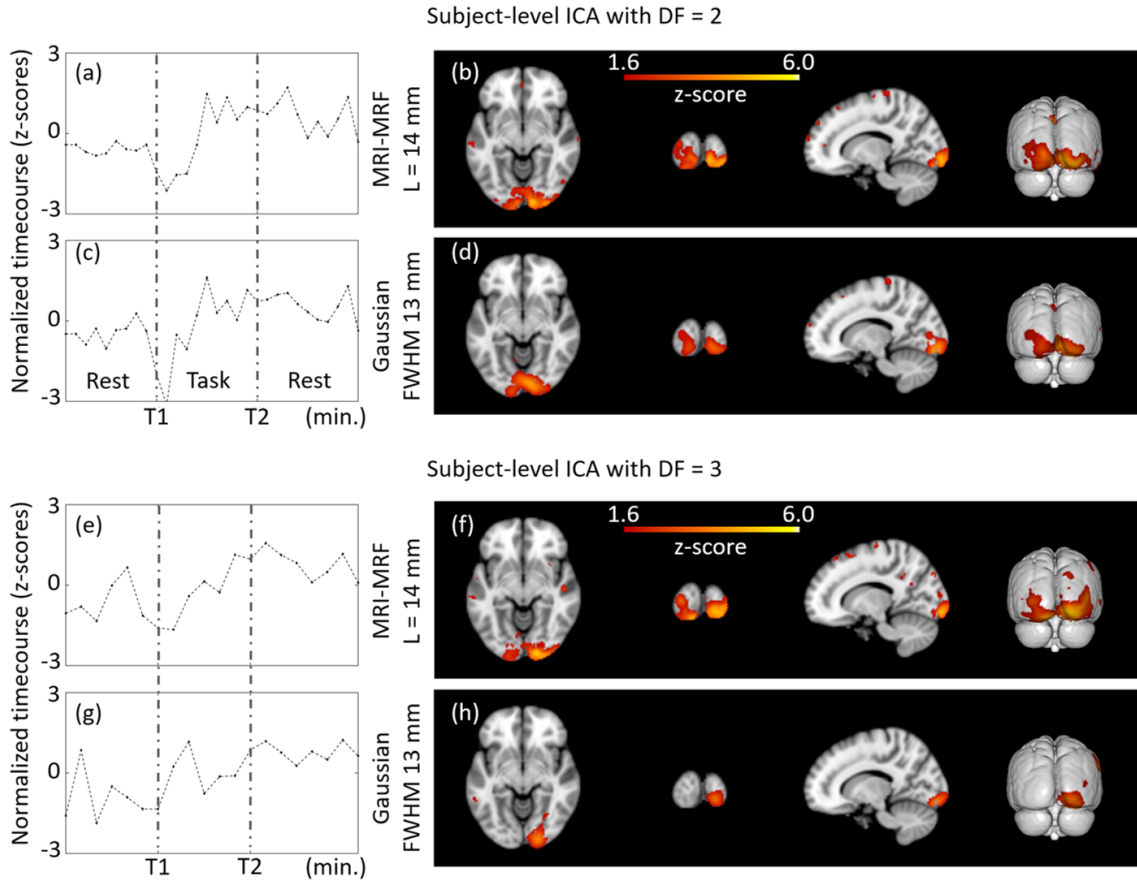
Subject-level (representative) estimation of brain activations using the reduced task and resting blocks with DF = 2 and 3: MNI coordinates (14, -94, -8). The independent components estimated from the filtered fPET images using different schemes are provided. DF = 2: MRI-MRF prior (b) and Gaussian kernel with FWHM 13 mm (d). DF = 3: MRI-MRF prior (f), and Gaussian smoothing with FWHM = 13 mm (h). The T1 and T2 represent the onsets of the task and second resting block, respectively.
